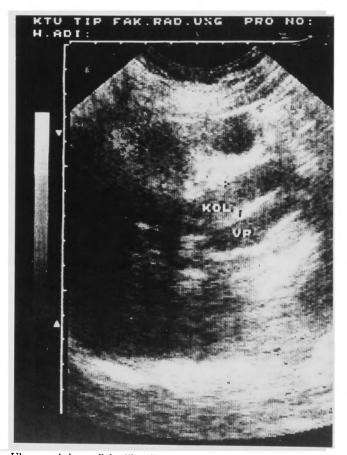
Ultrasound shows slight dilatation (1.4 cm) of the choledochus in the fourth case.
